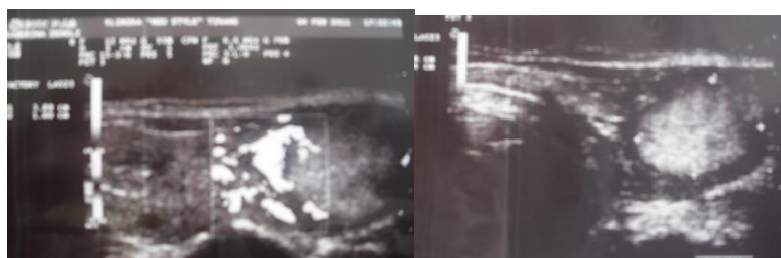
Sonogram shows a solid nodule that is hyperechoic with a hypoechoic thick halo in the left thyroid lobe, exhibiting irregular borders and perinodular blood flow.
